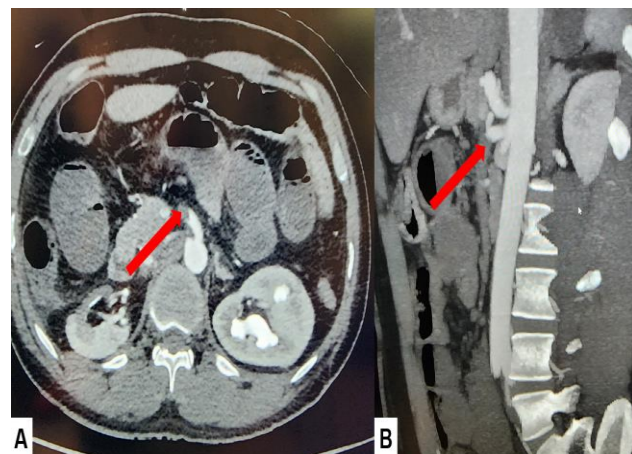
A. CT Abdomen w/ contrast (axial) demonstrating occlusion at the Superior Mesenteric Artery (red arrow), B. CT Abdomen w/ contrast (sagittal) demonstrating occlusion at the Superior Mesenteric Artery (red arrow)
